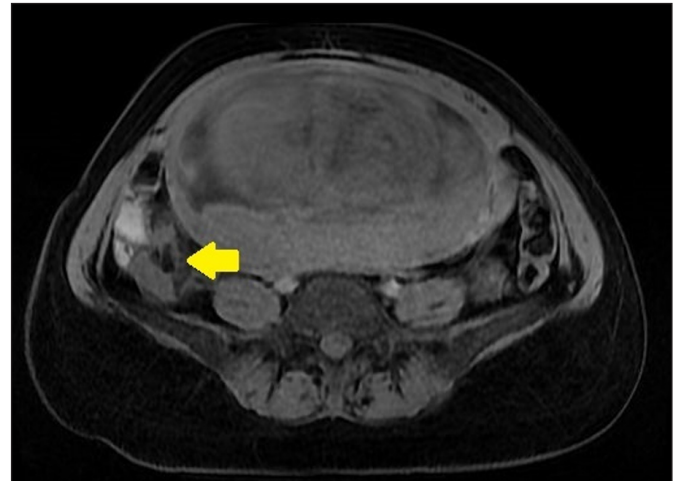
Fat-Suppressed T1A MRI Examination of the Patient Diagnosed with Acute Appendicitis.
